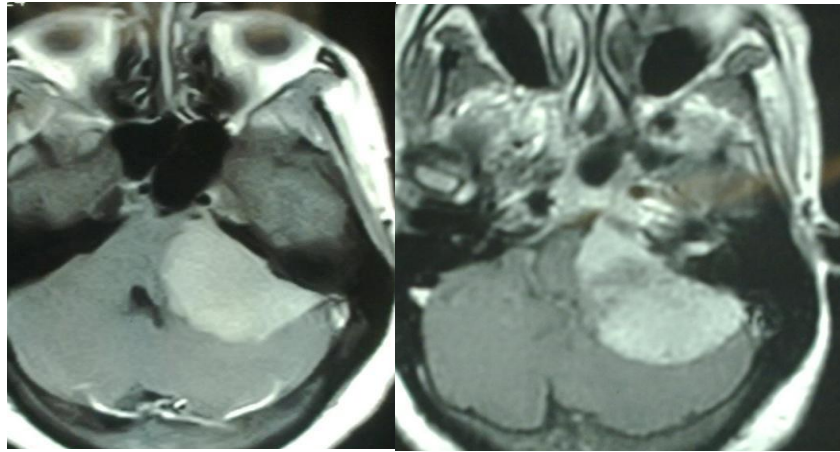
Case 3c: Pre-embolization MRI with contrast    Case 3d: Post-embolization MRI with contrast
